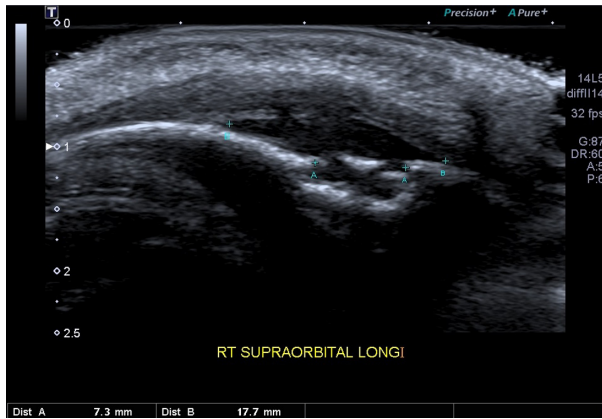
Longitudinal ultrasound image of the forehead lump with periosteal lifting (B callipers) and disruption of the underlying frontal bone (A callipers).
